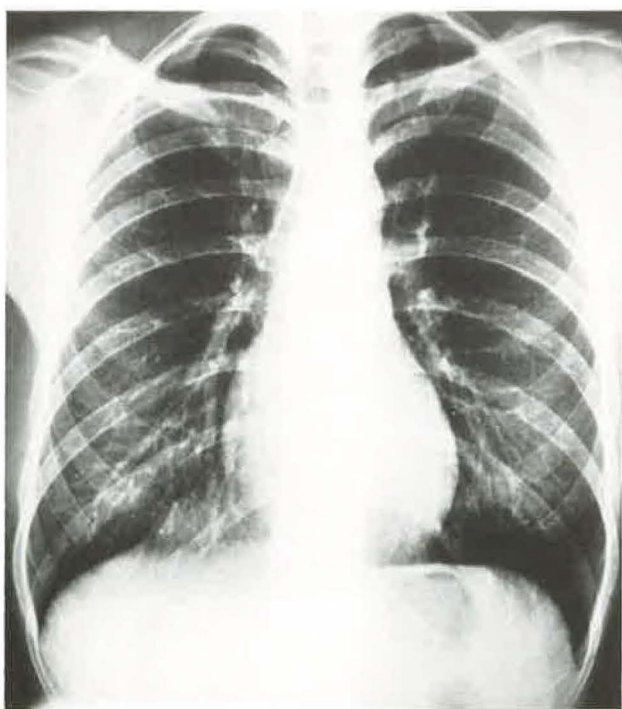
PA and lateral chest roentgenogram: mass in the right cardiophrenic angle. PA: Posteroanterior.
